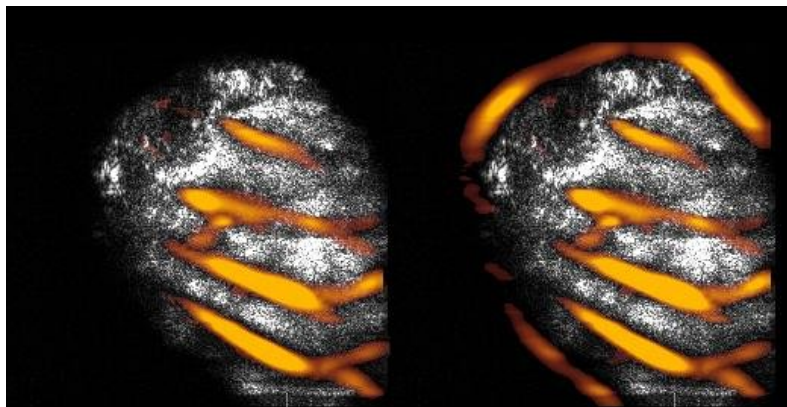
The output of the rib shadow detector after (on the left) and before masking (right). Notice the removal of false rib locations at the edge of the valid ultrasound region.
